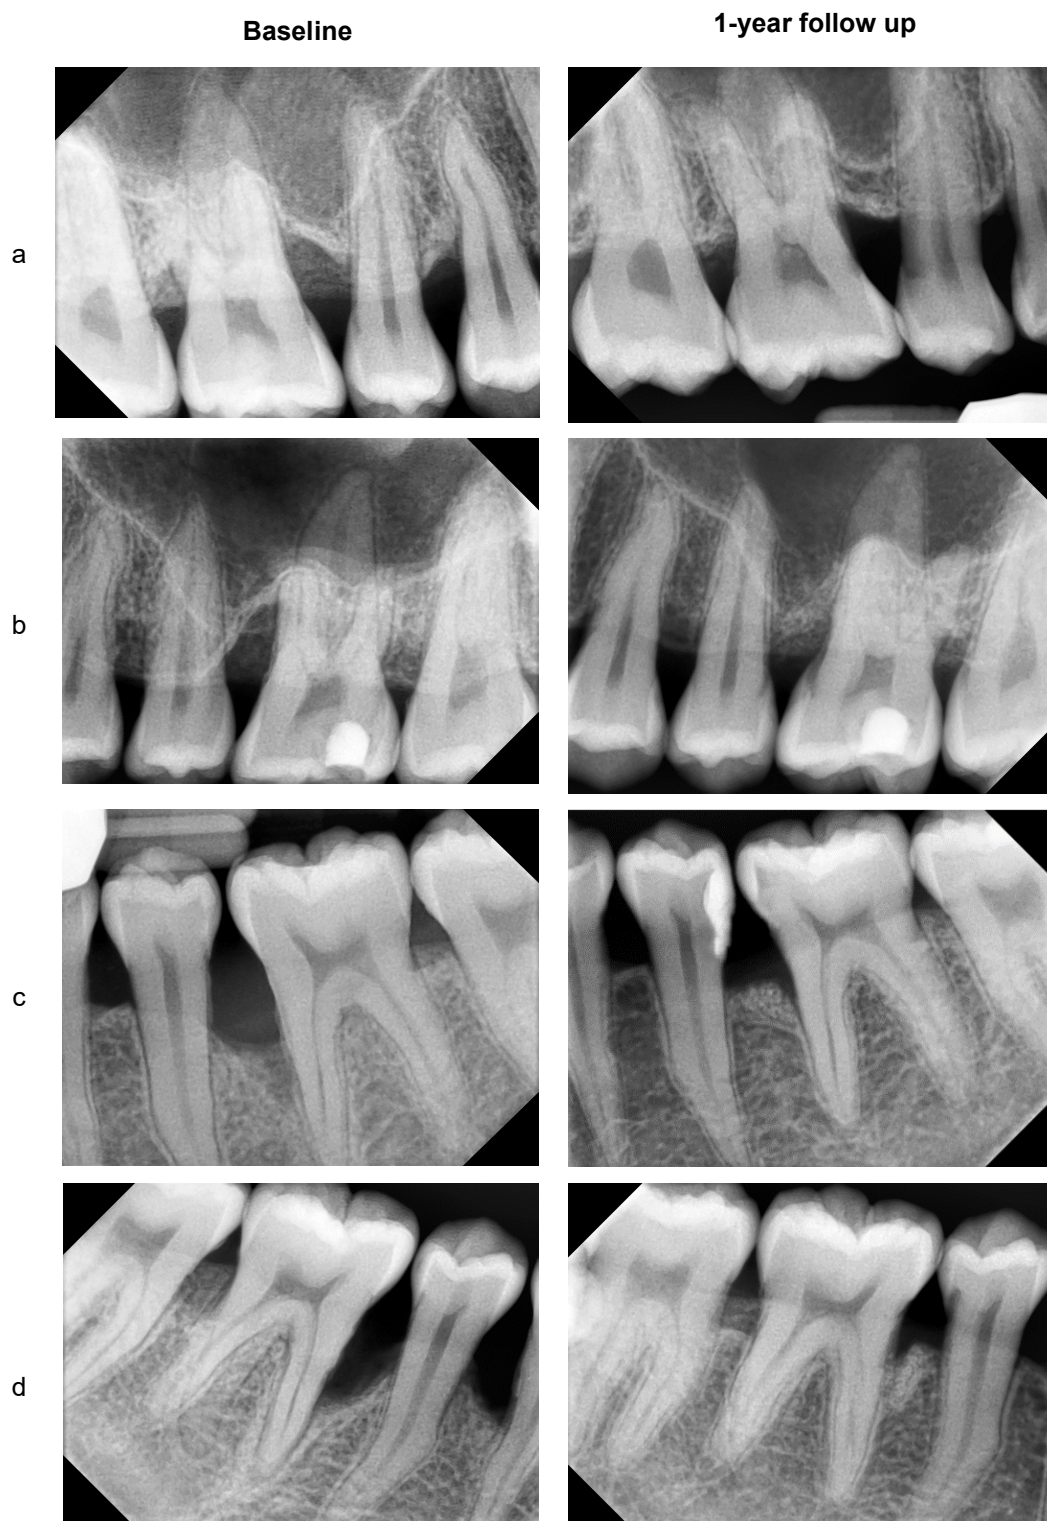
Pre-operative and post-operative (one-year follow-up) intraoral periapical radiographs of tooth a) 16, b) 26, c) 36, and d) 46.
